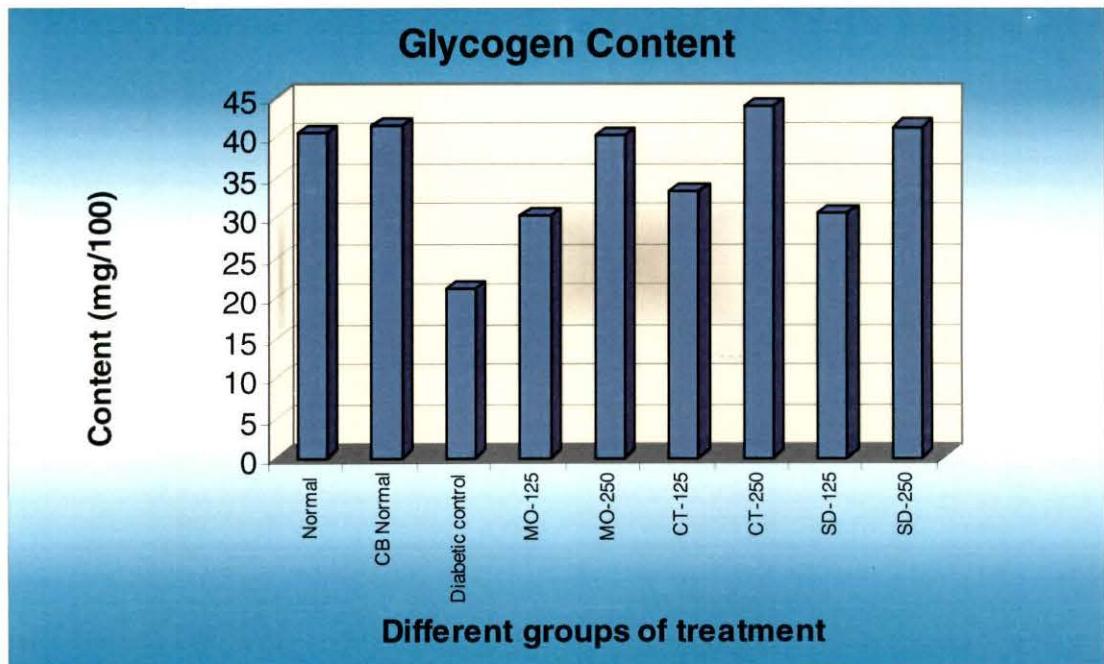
Effects of different extracts on glycogen levels. MO = *Moringa oleifera*, CT = *Cinnamomum tamala*, SD = *Scoparia dulcis*.
